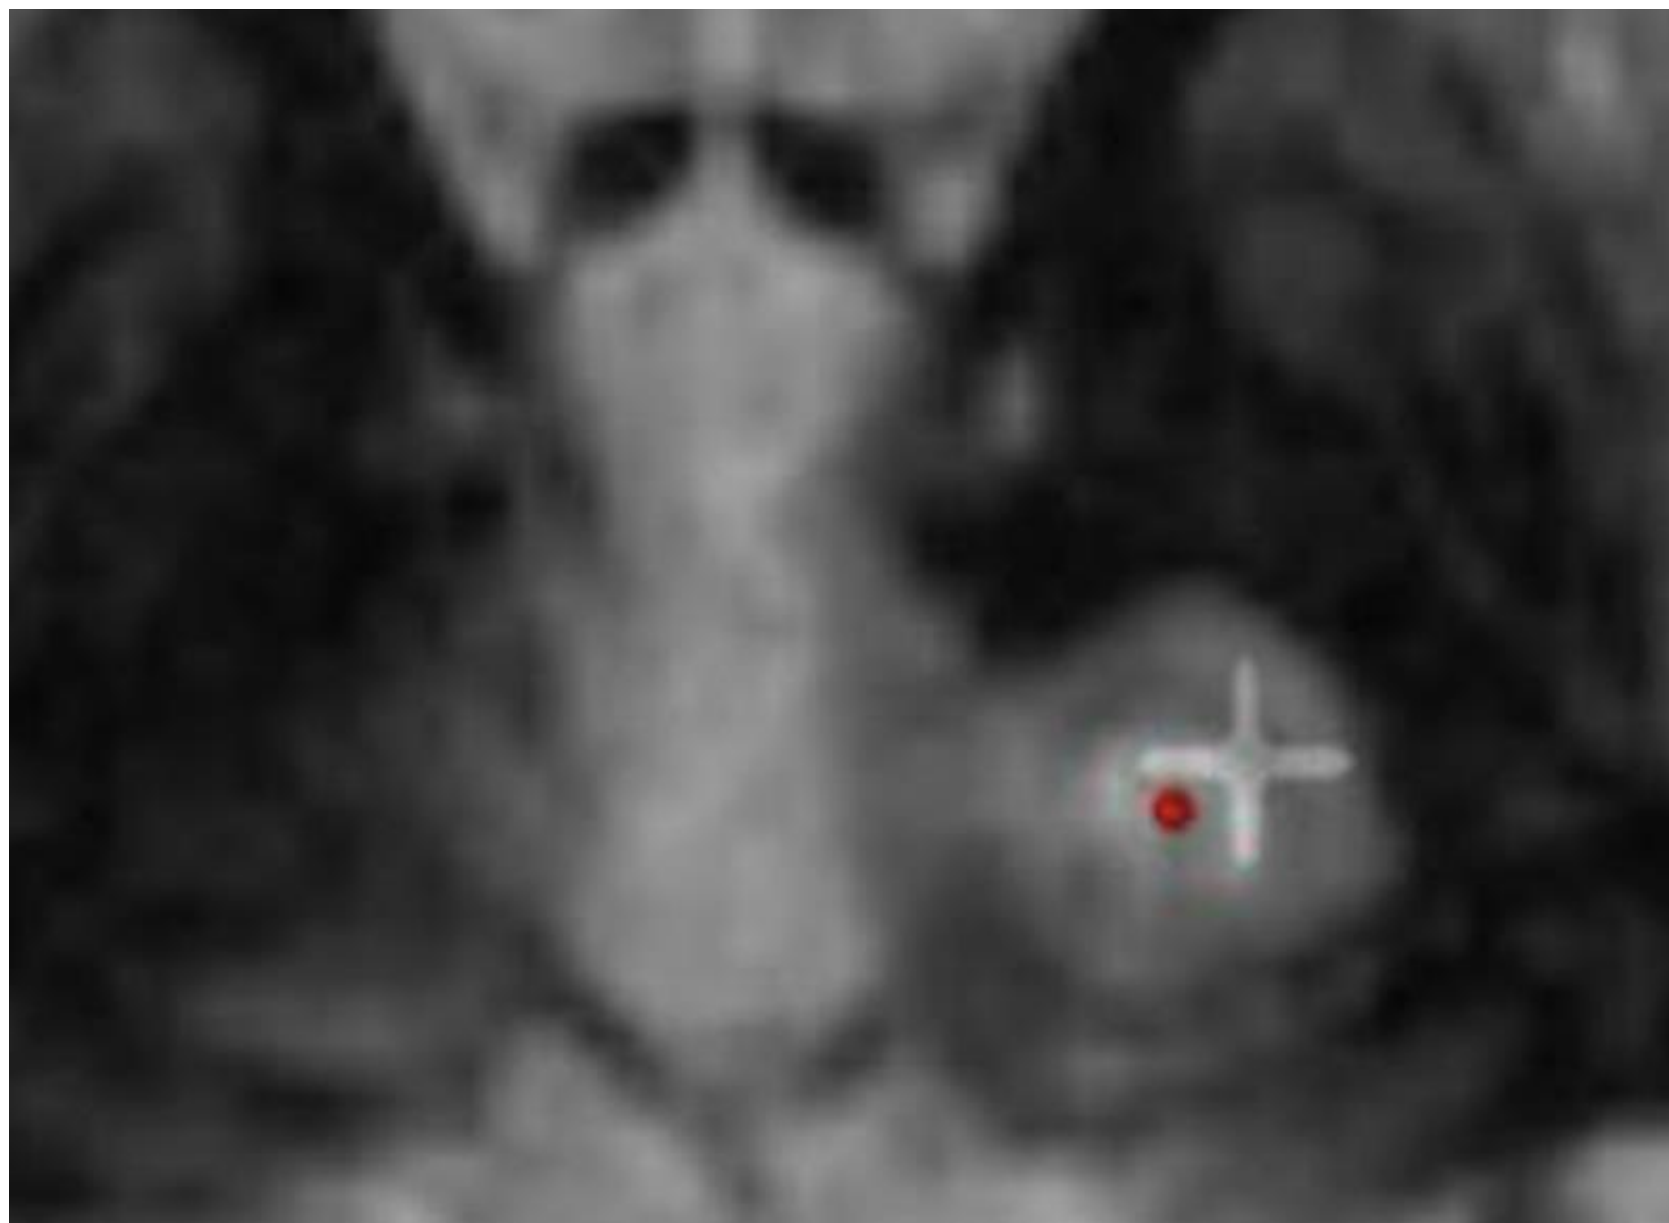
Axial Fast Gray Matter Acquisition T1 Inversion Recovery (FGATIR) MRI showing the AI-predicted target (plus sign) anterolateral to thalamotomy lesion (center at red dot) in a patient with persistent dysgeusia one year after surgery
